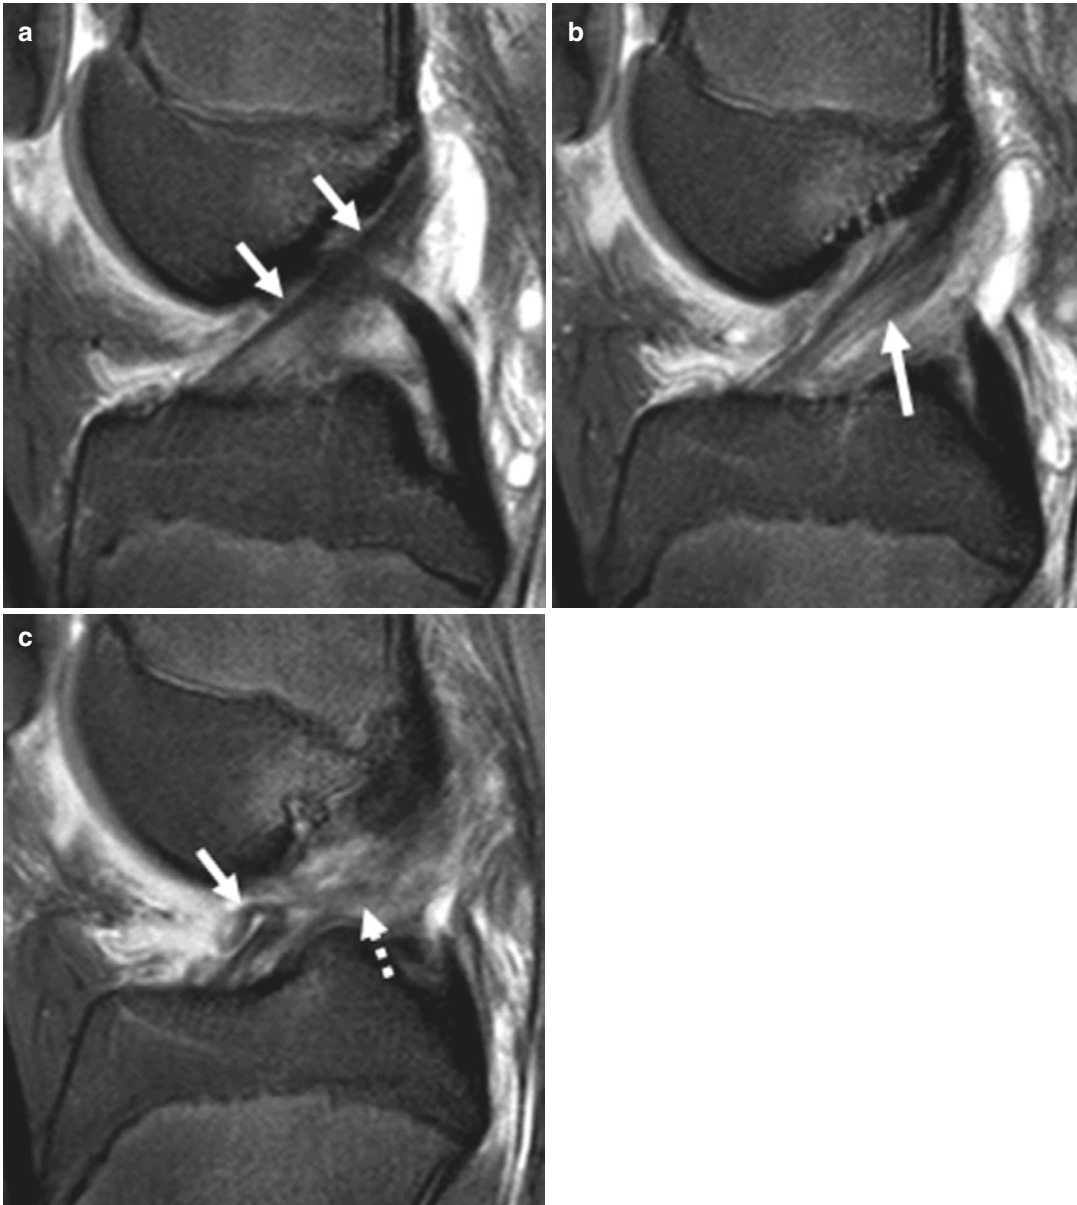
(a) Sagittal T2-weighted fat-suppressed image from a 14-year-old boy shows the normal appearance of the anteromedial bundle of the ACL, which is intact (*arrows*). (b) Same patient one slice lateral demonstrates hyperintense intrasubstance signal with thickening although fibers still appear intact. (c) One further slice lateral demonstrates
